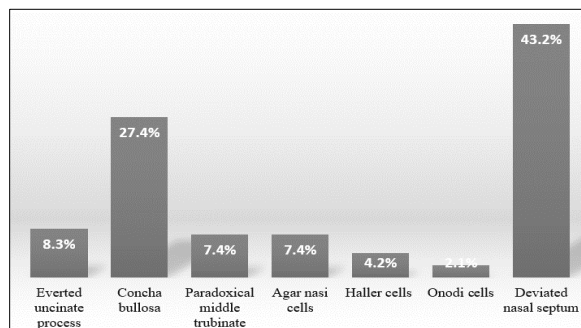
Frequency of anatomical variations in the CT scan findings of subjects with chronic sinusitis
